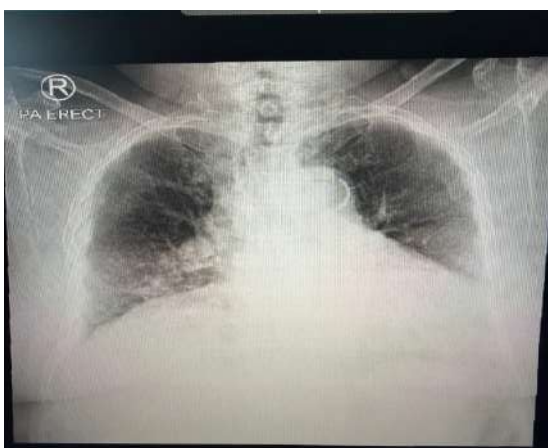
Chest X-Ray Examination Result
